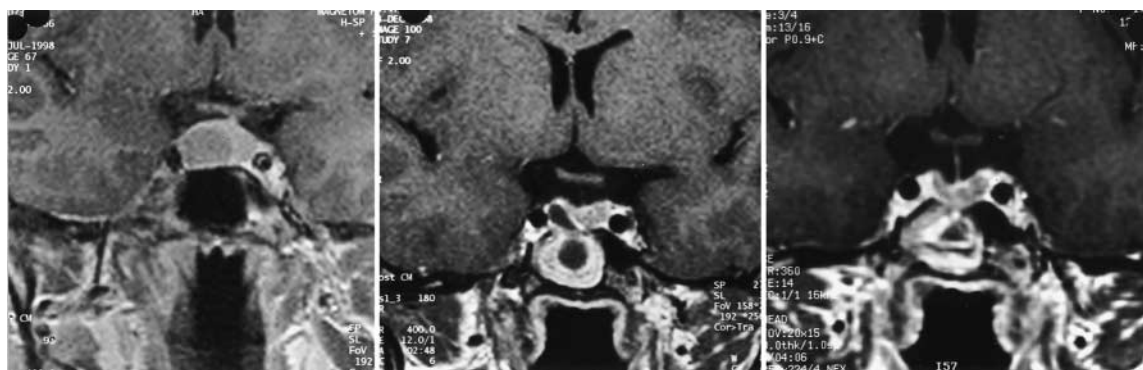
Coronal T₁-weighted MR images obtained after intravenously administered Gd-DTPA in a patient with a me-soprolactinoma. *Left:* Preoperative study. *Center:* Postoperative MR image obtained at 2 months, demonstrating significant scarring. *Right:* These changes are still partially recognizable in the 1-year postoperative follow-up MR image. However, the sellar contents can be well distinguished. The patient has been cured of her prolactinoma.
